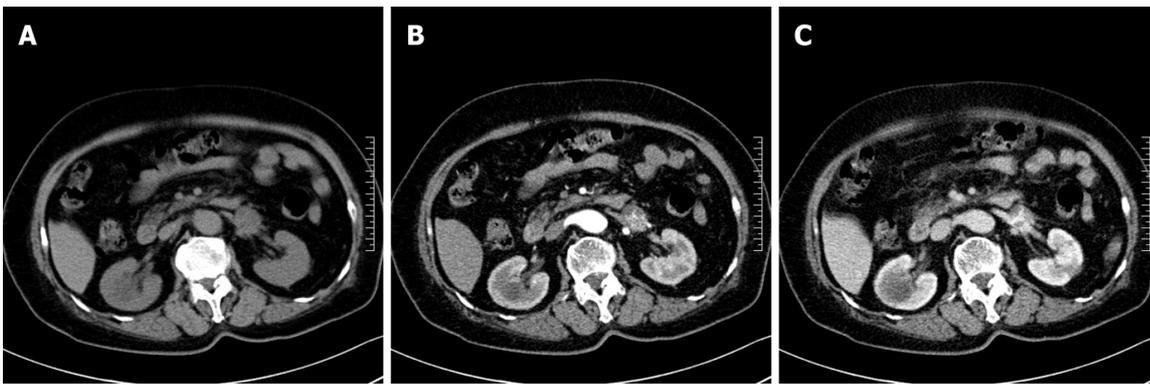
Anastomosing hemangioma of left renal vein on computed tomography. A: Non-contrast-enhanced scan; B: Arterial phase of contrast-enhanced scan; C: Portal phase of contrast-enhanced scan.
